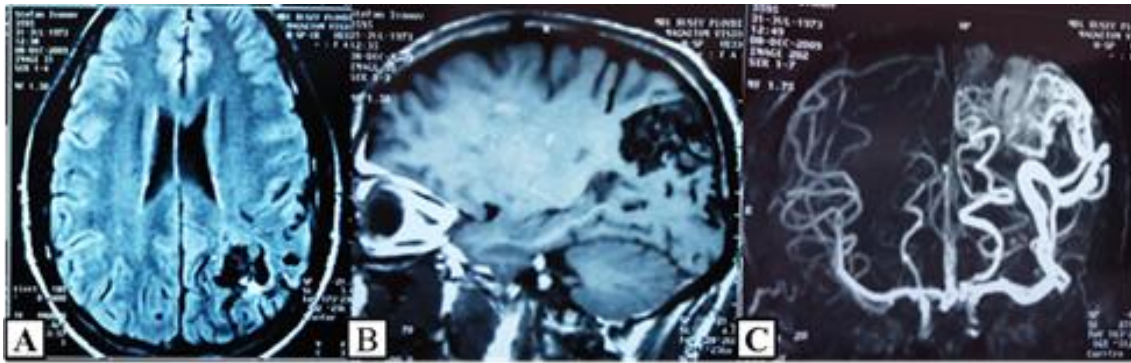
MRI images of AVM:
